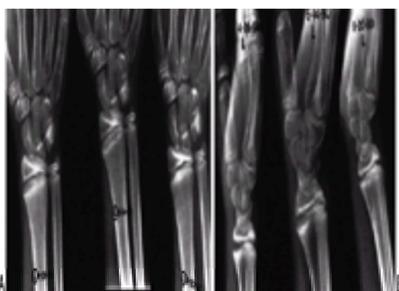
Sequential radiographs of the patient shown in Figure 31-3. She was asymptomatic 6 weeks after the initial presentation, and gradually returned to activities. She remained asymptomatic. The radiographs demonstrate progressive, but incomplete resolution. A: Anteroposterior radiographs were taken at the time of presentation, 6 weeks later and 5 months after initial presentation. B: Lateral radiographs show gradual resolution of the physal widening and metaphyseal cupping.
